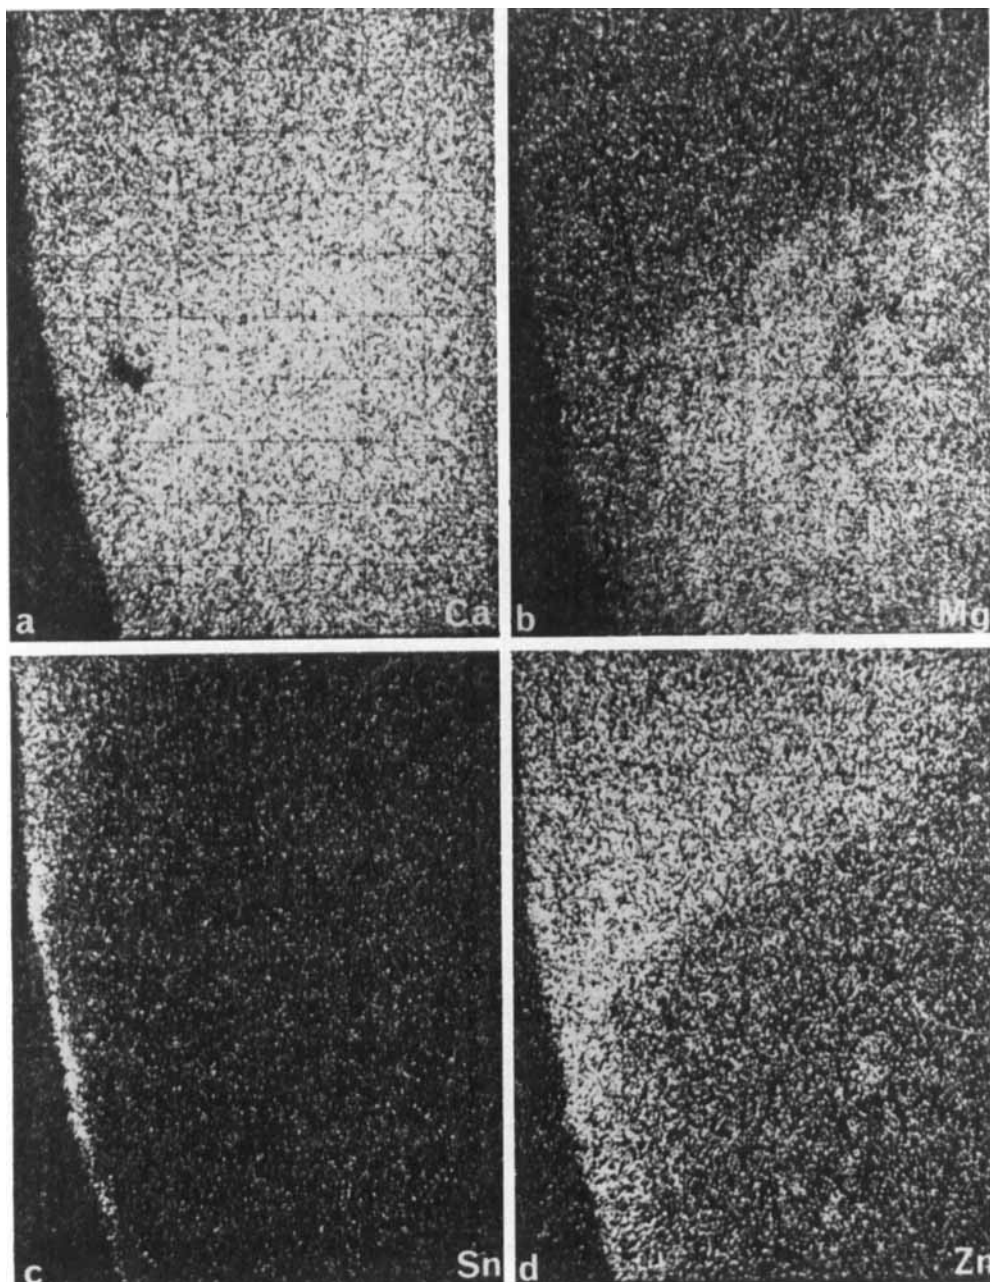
Elemental X-ray images of enframed area in Fig. 7. a) Ca b) Mg. c) Sn. d) Zn. $\times 530$.
